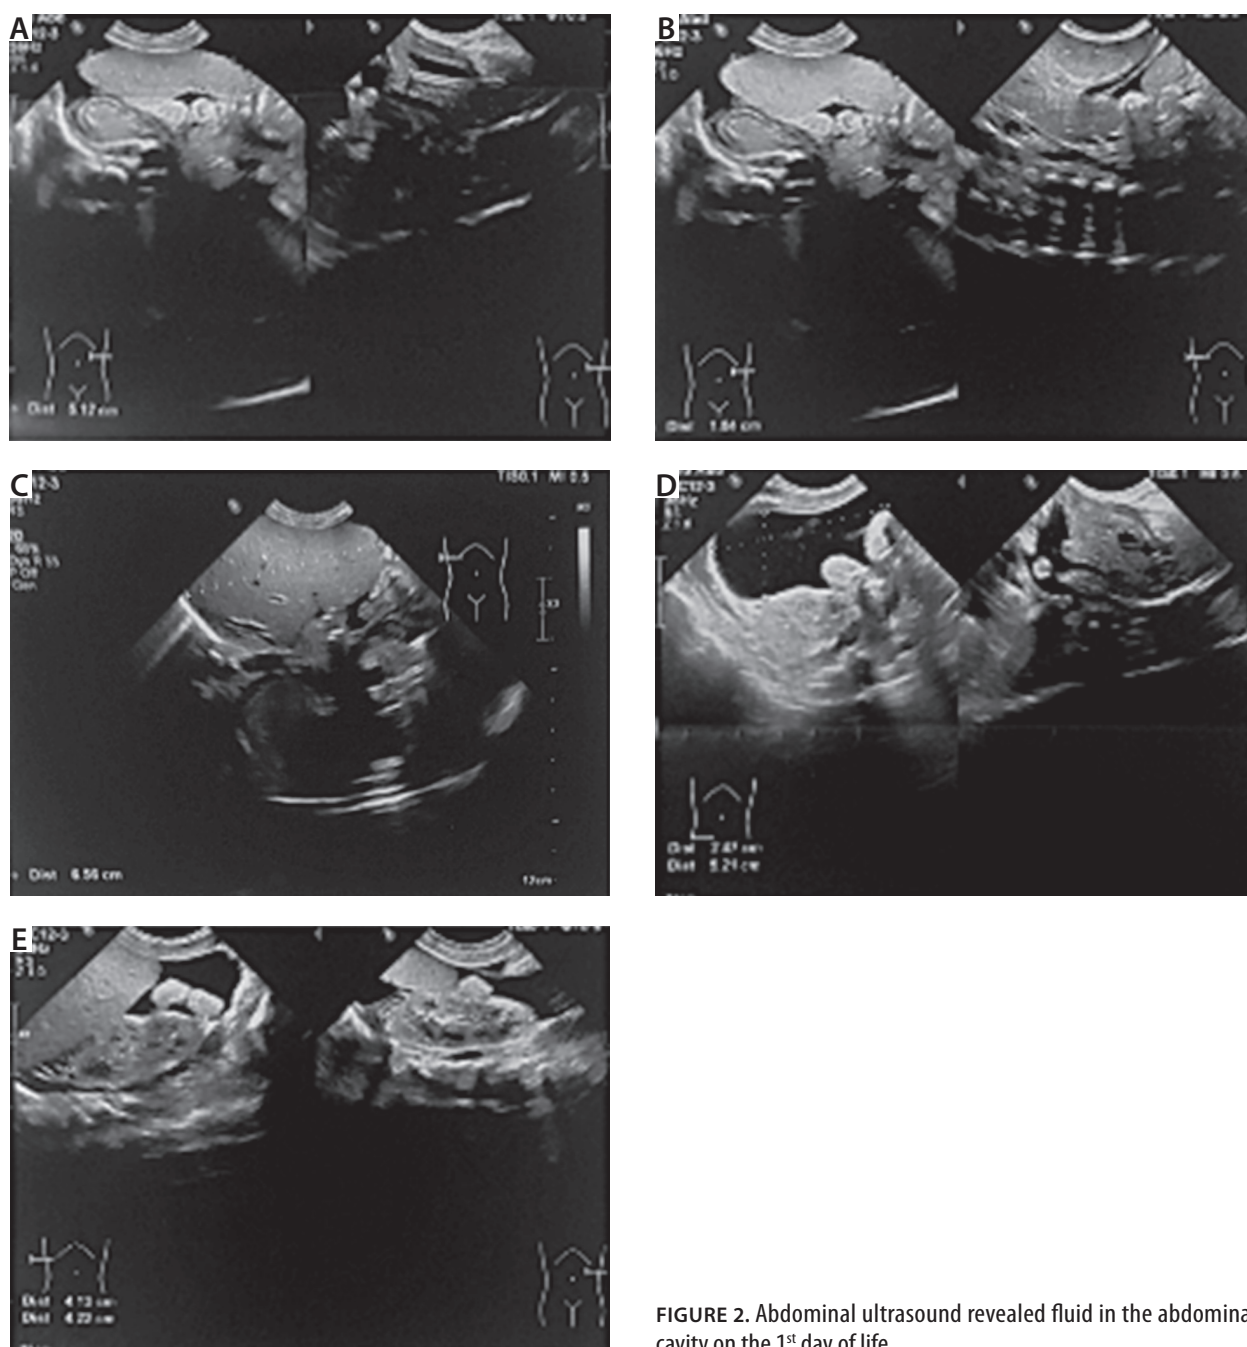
Abdominal ultrasound revealed fluid in the abdominal cavity on the 1st day of life
